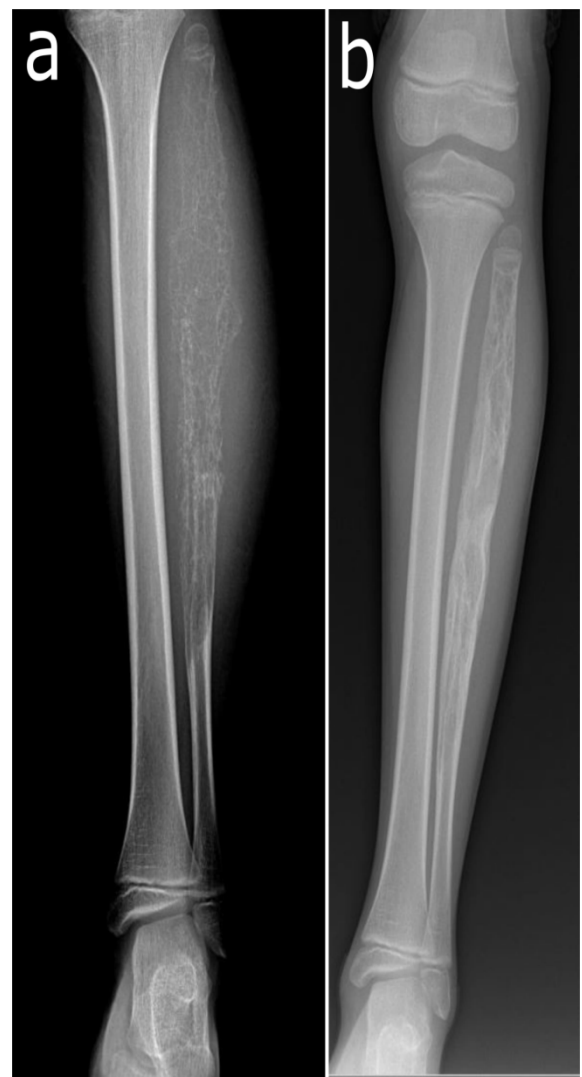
X-ray of the left fibula at presentation (a) and the end of the chemotherapeutic treatment (b).
